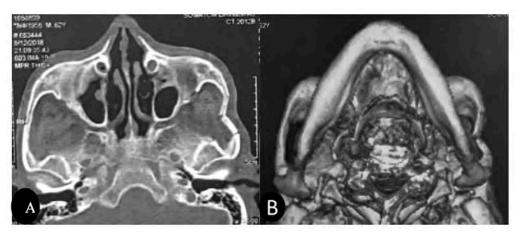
A) Computed tomography shows the hypodense line, these fractures can ben classified as a fracture of the left zygomatic arch. B) 3D reconstruction of computed tomography
